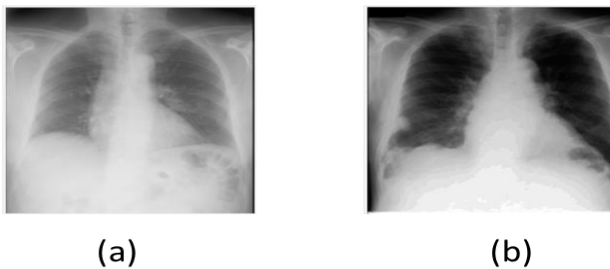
(A) Test X-Ray Figs. 4 (B), 4 (C), 4 (D) Top Four (Excluding The Original Image) Three Similar Images Retrieved After The Application Of Proposed CBIR Framework.
